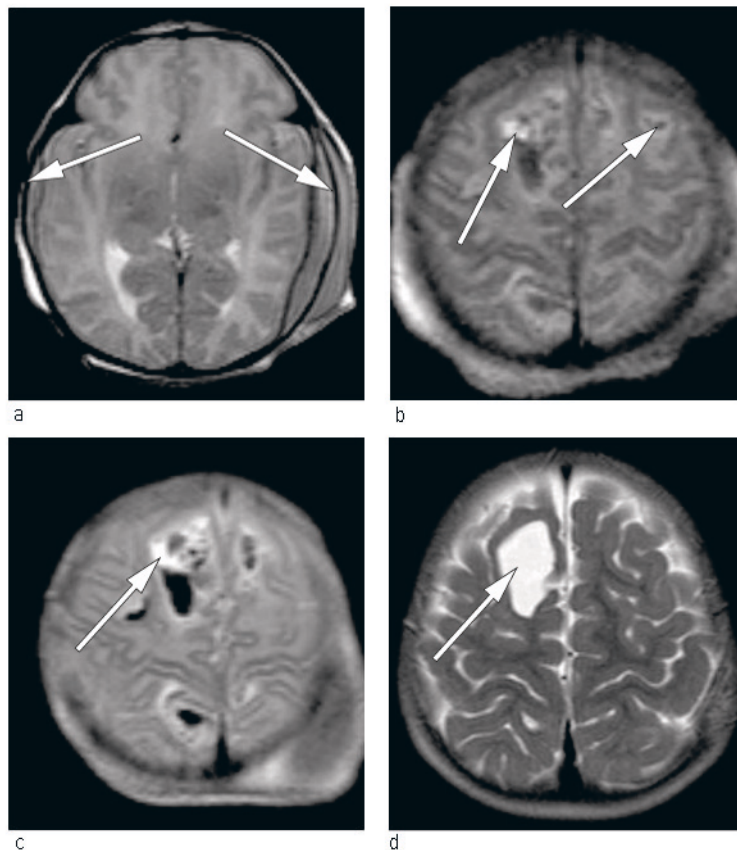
MRI of head, T2 image with 1.5 Tesla scanner. The images during the first day of life show a) fresh subdural haematomas (arrows) and b) mixture of fresh and 3–4 day-old intracerebral haematomas (arrows). c) Control after 24 hours shows an increase in the size of one intracerebral haematoma (arrow). d) After 15 months a cavity remains frontally after the largest intracerebral haematoma (arrow)
